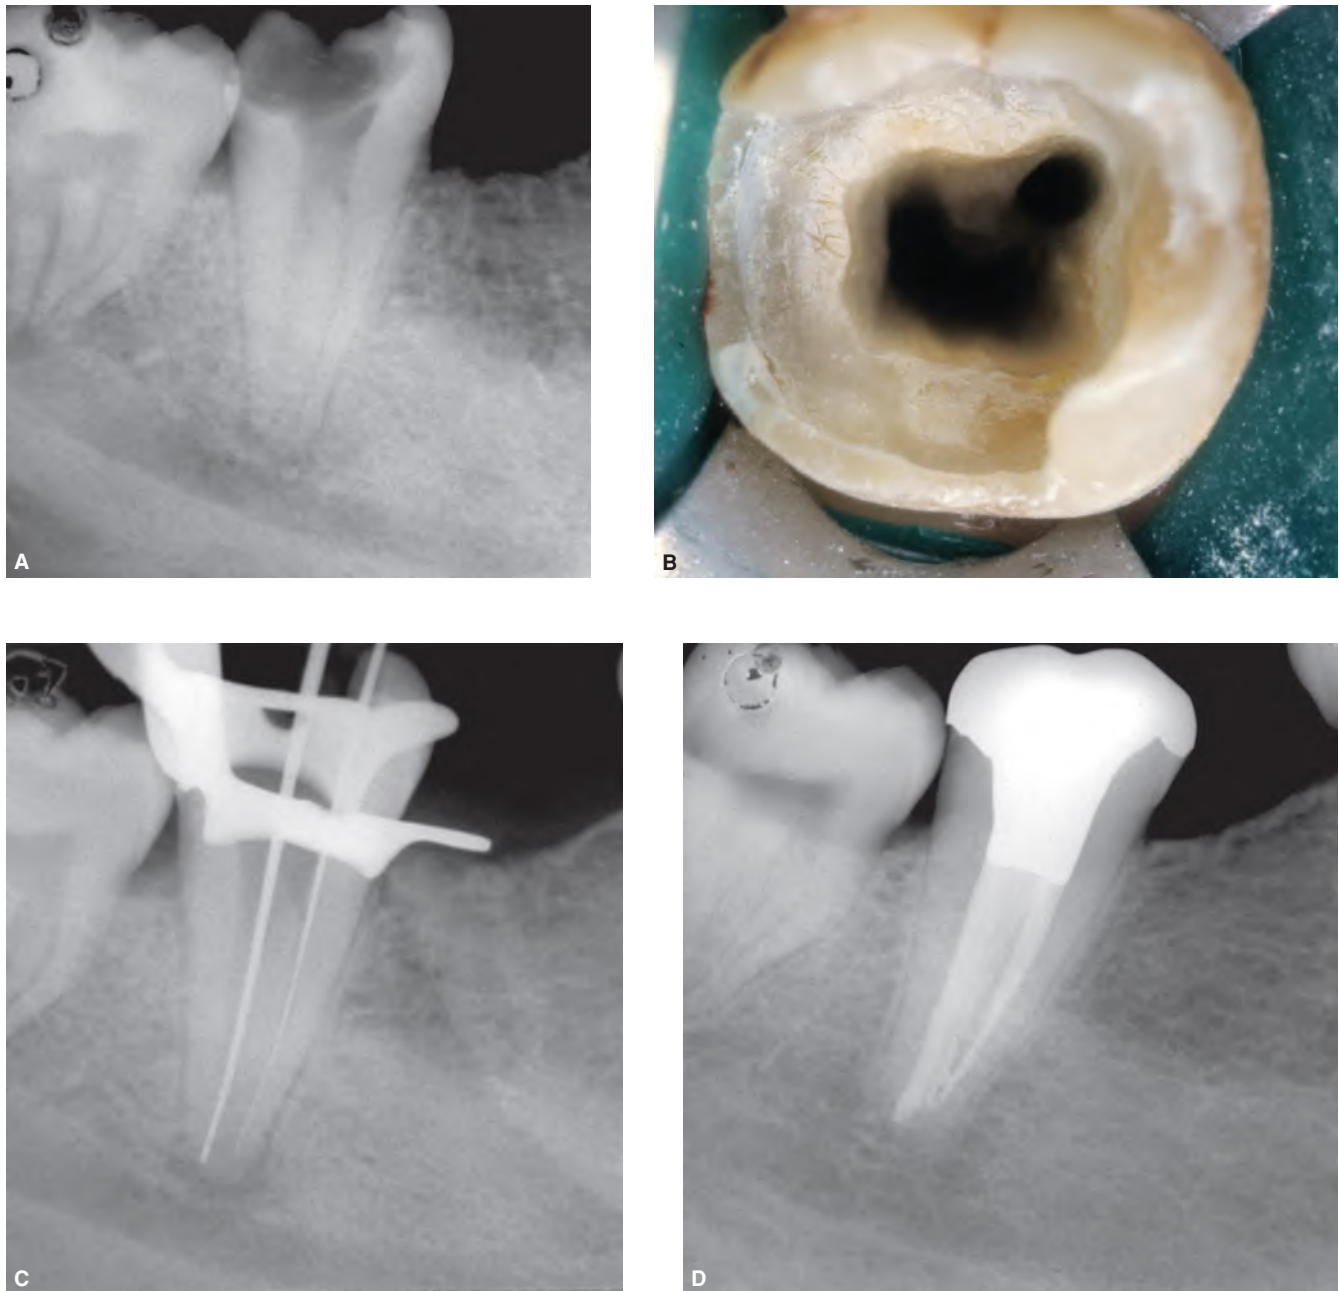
Endodontic treatment in a mandibular second molar with C-shaped canal and necrotic pulp of a 25-year-old male. A. Preoperative radiograph showing the affected tooth associated with a periapical radiolucency. B. Clinical view of the access cavity showing an independent mesiolingual canal and a C-shaped configuration connecting the mesiobuccal canal to the distal canal. C. Working length assessment radiograph. D. Three-year recall radiograph showing resolution of the periapical radiolucency. The patient is asymptomatic and the tooth is functional. (Courtesy of Dr. Domenico Ricucci, Cetraro, Italy. Adapted with permission from Ricucci et al.¹⁴⁷)
